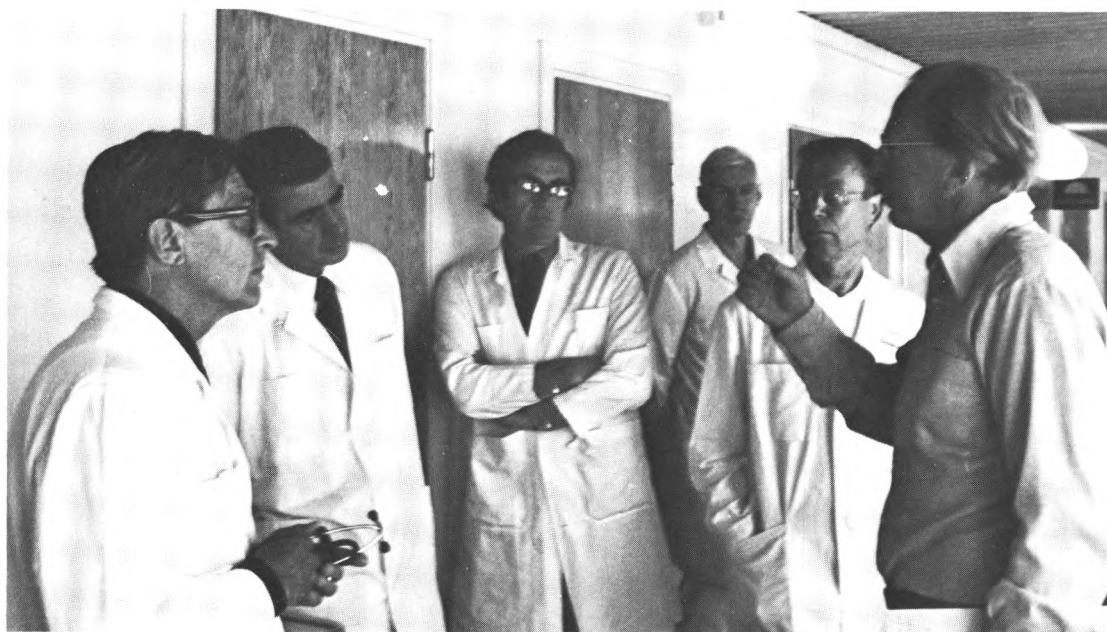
Discussion after the x-ray round. From left to right: Björk, Pluth (Mayo Clinic), Smith (Sheffield), Koivistu (X-ray Dept.), Törnell (Head of X-ray Dept.) and Holmgren (Head of Clinical Physiology).
